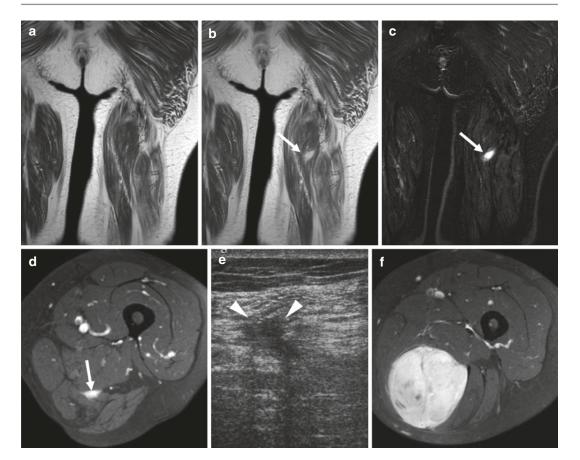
(a–f) Local recurrence of pleomorphic sarcoma 4 years after surgical resection. (a) Coronal T1-weighted TSE, (b, c) corresponding contrast-enhanced T1-weighted and subtraction image, and (d) transverse fat-suppressed contrast-enhanced T1-weighted TSE image show contrast-enhancing nodular lesion (*arrows*)
